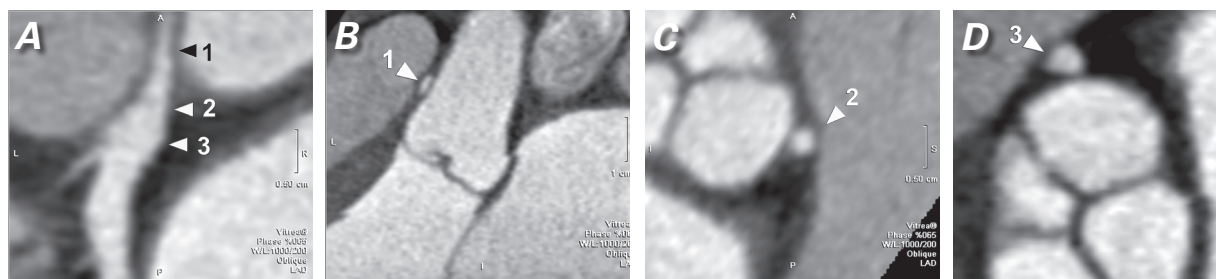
Computed tomographic angiograms of the left main trunk, which exits the aortic wall (not imaged with this technique). A) Sites 1, 2, and 3 are the locations from which the cross-sections of the left main trunk (Figs. B, C, and D, respectively) were obtained; the calculated cross-sectional areas are shown in parentheses. B) 1: intramural proximal left main trunk (5.7 mm²); C) 2: borderline segment (11.2 mm²); and D) 3: extramural distal left main trunk (16.7 mm²). As shown, the intima is always thin throughout the left main trunk, and the extramural proximal left main segment that appears smaller in angiography is round and progressively larger, in order to reach the relatively ectatic left main coronary artery at its bifurcation. The stenotic effect at that level is unsubstantiated (see text).
